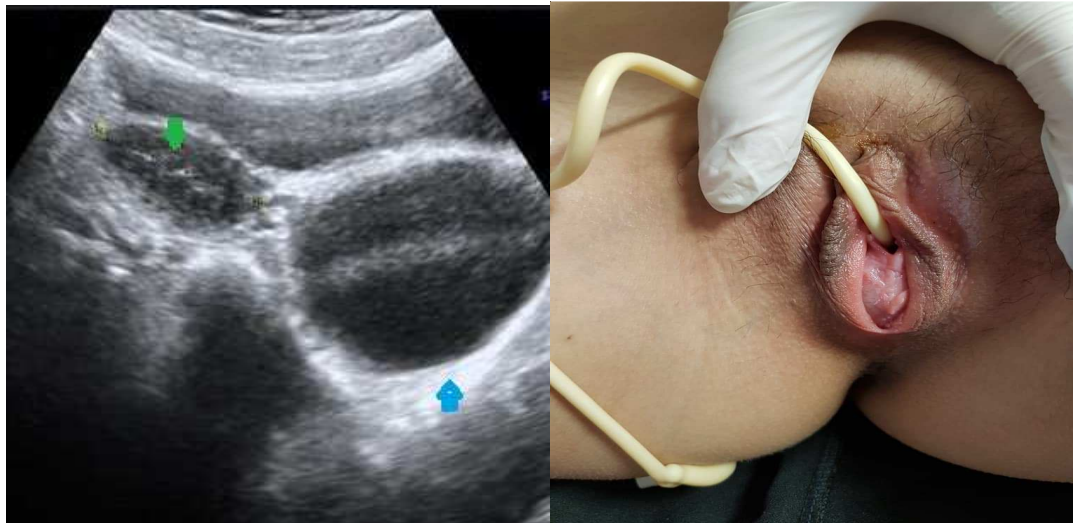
Transabdominal short-axis female pelvic ultrasonography showing a large hematocolpus (blue arrow) and a normal size empty uterus (green arrow).
